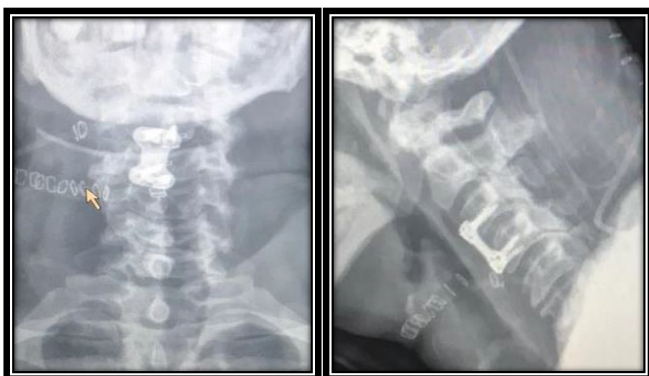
Post-surgical x-ray imaging showing the implant at C3/ C4 spine segment.
